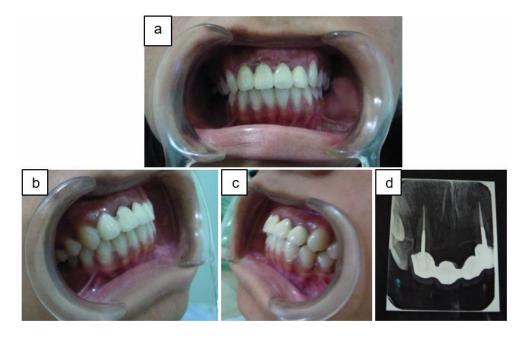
(a) Fixed insertion of fixed-fixed bridge crowns for teeth 12, 11, 21 and, 22 made of porcelain fused to metal (PFM) and the photo is seen from the front (b) right side, (c) left side, and (d) X-ray results after the installation of a porcelain fused to metal (PFM) fixed-fixed bridge crown.
